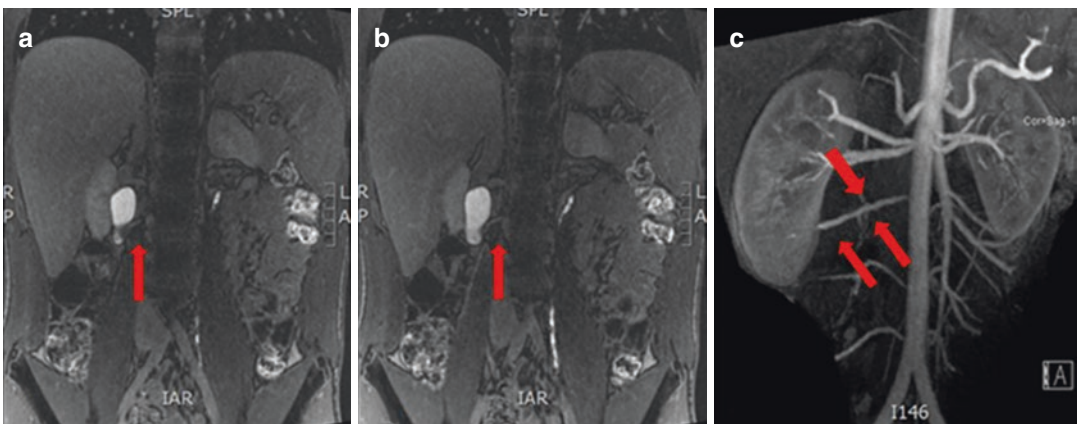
(a, b) MRI showing the aberrant vessel crossing the right renal pelvis; (c), three-dimensional reconstruction
